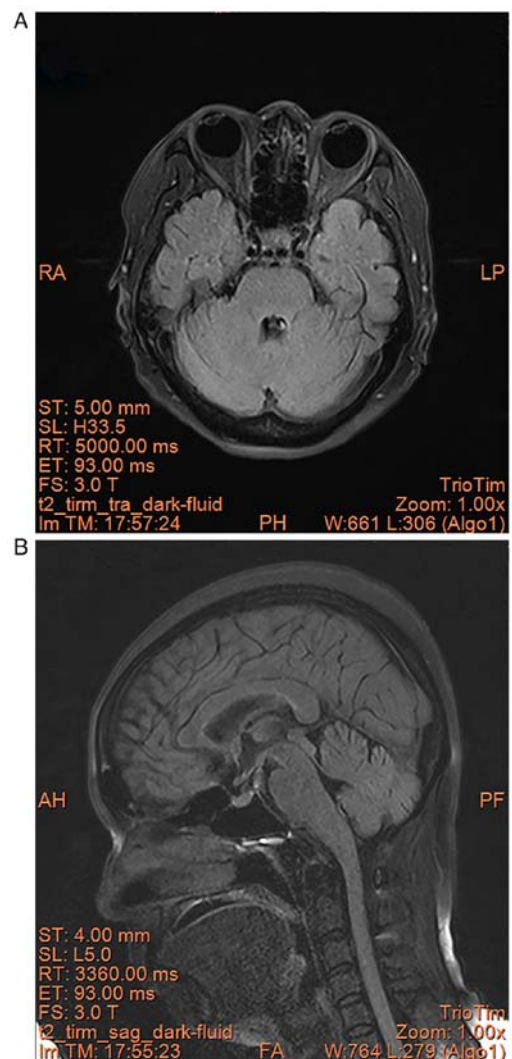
Brain MRI results. No significant abnormality could be seen (A) axial and (B) sagittal views. RA, right anterior; LP, left posterior; AF, anterior frontal; PH, posterior head.
